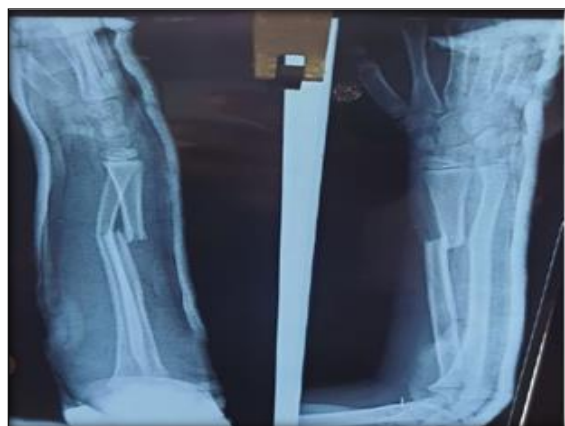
Pre-op x-ray showing displaced both bone forearm fracture
